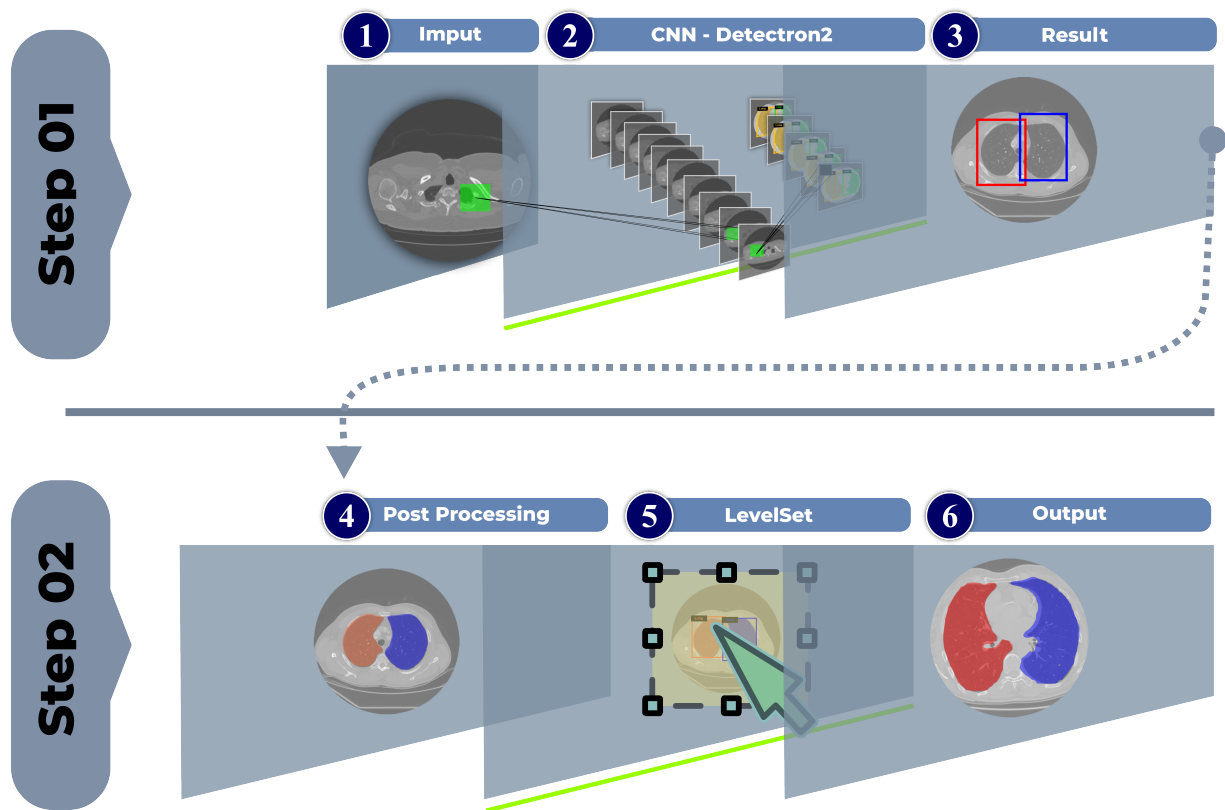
It presents the methodology of this study, which is divided into two stages; Detection Step (Image 1-Input: Input of the CT image into the model, Image 2-CNN Detectron2: Image detection process, and Image 3-Results: Results of detection through the bounding box), The Segmentation Step (Image 4-Post-Processing: Using Dilation of the output image in the previous step, Image 5-LevelSet Method: Process of readjusting the lung regions and Image 6-Final Result: Showing the segmentation of the Lungs.
